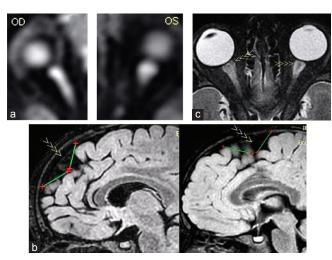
Brain MRI (a) Diffusion weighted showing extensive fluid around optic nerves. (b) Hygroma, unusual in a child. (c) Greater than 2-mm of CSF in optic nerve near globe.
